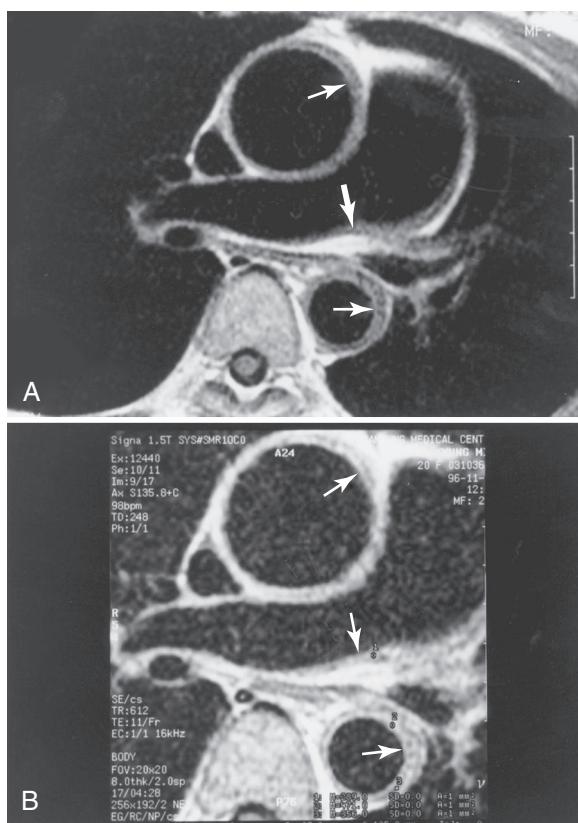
Clinically Active Takayasu Arteritis in a 25-Year-Old Woman. (A) A T1-weighted axial magnetic resonance image before contrast media injection shows diffuse and concentric mural thickening of the thoracic aorta (thin arrows) and mild mural thickening of the right pulmonary artery (thicker arrow). (B) Immediately after contrast media injection, a T1-weighted axial image shows enhancement in the thickened aortic and pulmonary arterial walls (arrows), which suggests increased vascularization in the inflamed vessel walls. (From Choe YH, et al. Magnetic resonance imaging diagnosis of Takayasu arteritis. *Int J Cardiol*. 1998;66(Suppl 1):S175–S179.)
